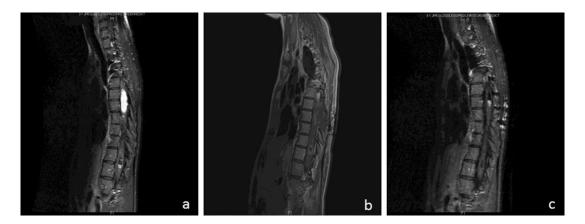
Sagittal T1 with gadolinium thoracic MRI depicting PMA. a One month before partial resection.b Immediately postoperatively. c Nine months after initiating chemotherapy.
